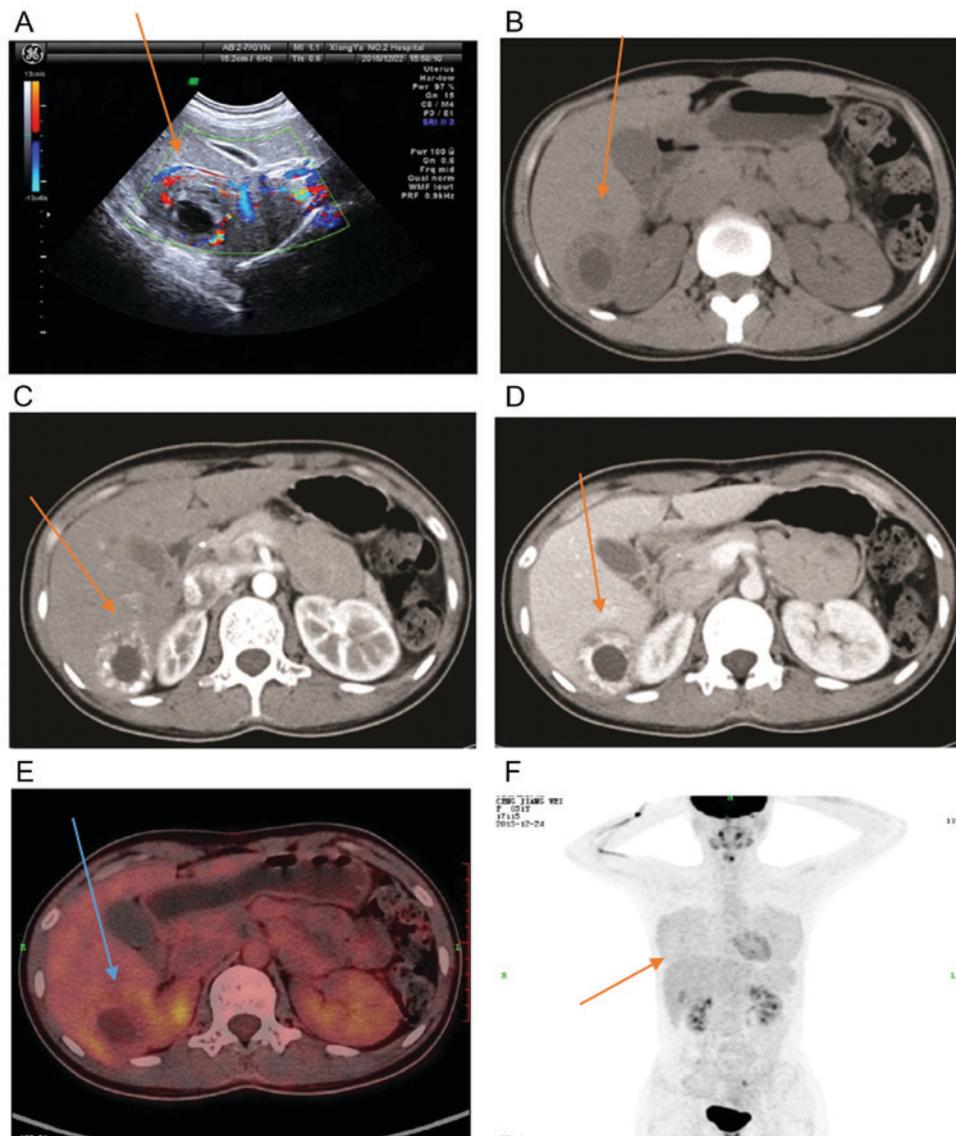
Imaging results for the patient with ectopic pregnancy in the liver (A) Ultrasound image. (B) CT plain scan. (C) Arterial and (D) venous phases in the enhanced CT scan. (E) Positron emission tomography-CT. (F) Positron emission tomography-CT maximum intensity projection image. Orange arrows indicate the location of the ectopic pregnancy mass. CT, computed tomography.
